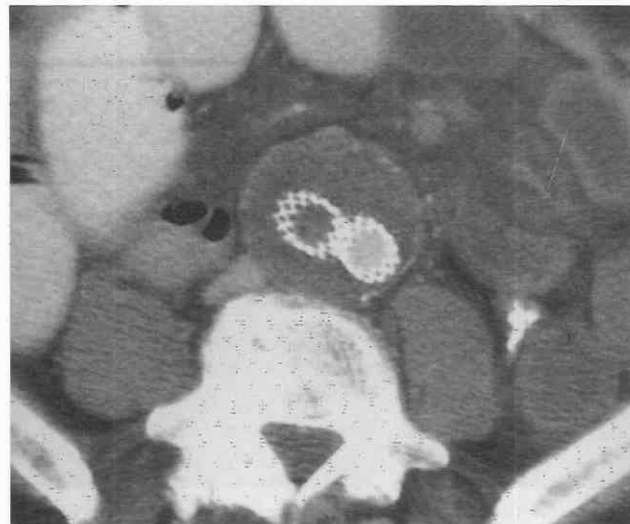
Endovascular stent-graft with thrombosis of a limb. Intravenous contrast-enhanced CT scan in a 68-year-old man who had undergone insertion of an endovascular stent-graft (2 months earlier) reveals contrast-enhanced blood flowing through the left common iliac limb but no enhancement in the right common iliac limb. The right limb is completely thrombosed. The aortic aneurysm surrounding the graft is also completely thrombosed but is still quite large, probably because the thrombus there has not had time to be resorbed.
